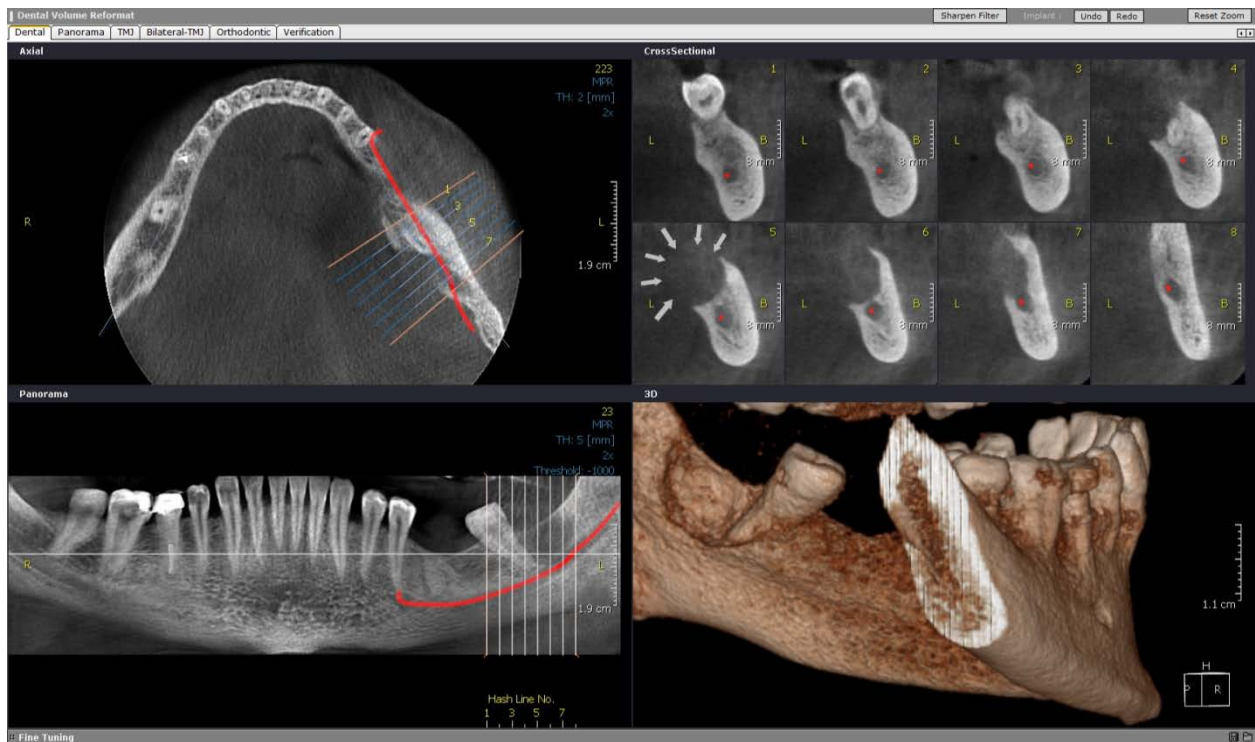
Axial, Cross sectional, Panorama and 3D CBCT images represent a well defined radiolucent lesion (white arrows) with perforation (white arrowheads) in the posterior area of left mandible
